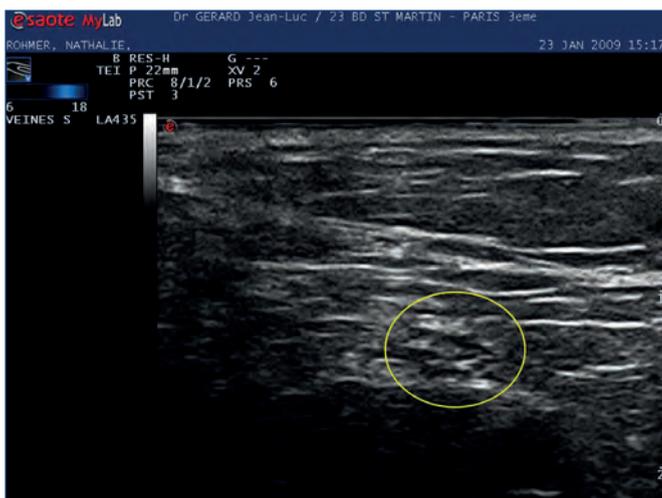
Cross-section of the tibial nerve using an 18 MHz ultrasound probe that shows the classic honeycomb shape (yellow circle).
